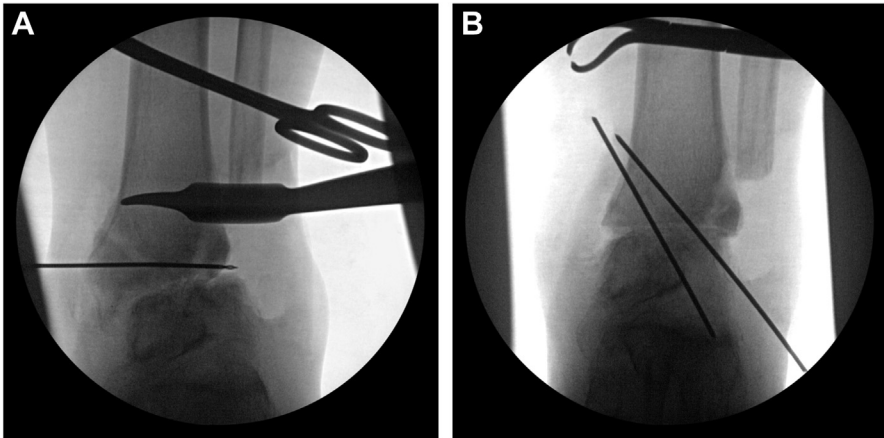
(A, B) Intraoperative radiographs depicting the use of a kirschner wire to determine the appropriate orientation of the flat cut orthogonal to the longitudinal axis of the tibia.
